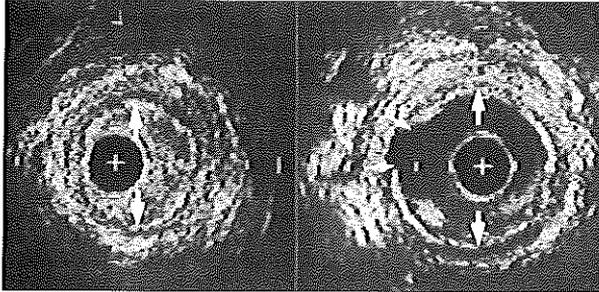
Intravascular ultrasonographic cross sections obtained from superficial femoral artery at corresponding levels before (*left*) and after (*right*) balloon angioplasty with 6 mm diameter balloon. No angiogram was available before intervention because of origin obstruction of superficial femoral artery. Before laser angioplasty, ultrasound catheter was advanced blinded proximally to distally through lesion. Ultrasound catheter is seen to be completely surrounded by soft concentric lesion. Hypoechoic media is circumferentially seen, indicating diameter of vessel of 3.5 mm (between *arrows*). After intervention, lesion for major part has disappeared; diameter of vessel increased to 4.5 mm. Internal elastic lamina rupture is seen at 9 o'clock position evidenced as interruption of internal elastic lamina echoes (*small arrows*). *Plus sign* indicates catheter; calibration, 1 mm. (Reprinted in part with permission of Circulation from The SHK, Gussenhoven EJ, Zhong Y, et al. Circulation 1992;86:483-93.)
